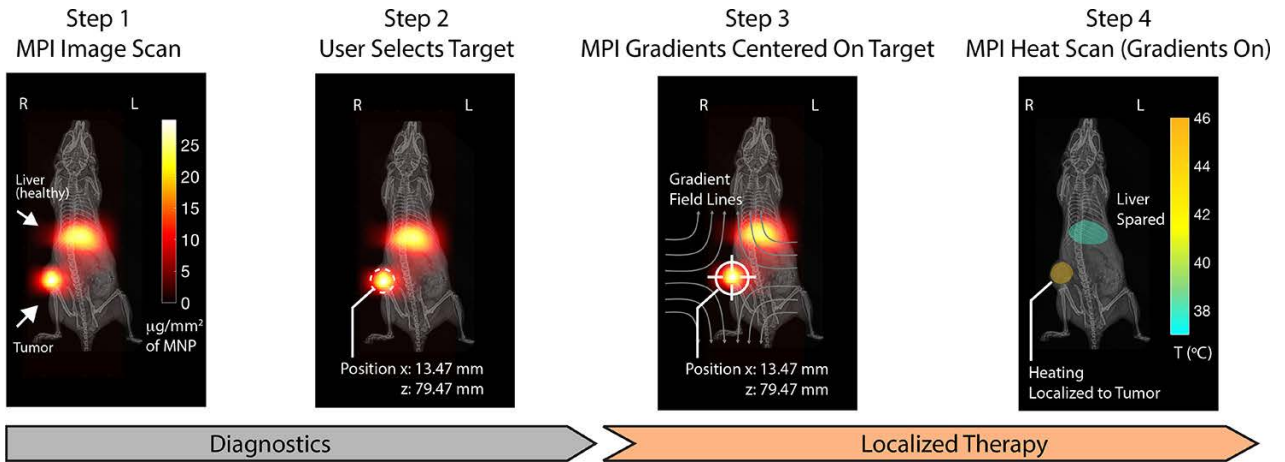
Magnetic hyperthermia therapy consists of diagnostics and therapy phases. MPI images were obtained with a 2.35 T/m selection field (FFL) and 20 mT excitation field at 20 kHz. (Step 1) MPI images of the healthy and tumor region were overlaid to the static MRI image, (Step 2) The position of the tumor region was determined after diagnosis, (Step 3) Tumor region was localized with a gradient field to contain the heating region, (Step 4) Excitation field of 13 mT at 354 kHz were applied to generate heat with same tracer agent in the presence of gradient field. Healthy tissues were protected with a localization approach to the tumor treatment. The image was adapted with permission from ACS publications [89].
